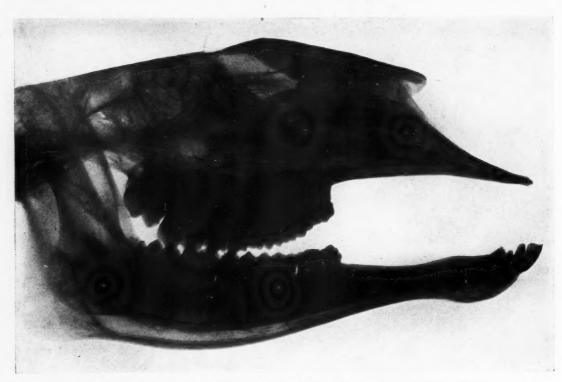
Radiograph of an antelope, showing hypsodont teeth attached by gomphosis.
